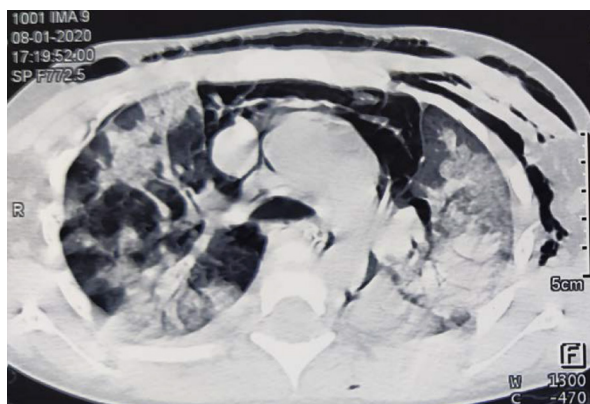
High resolution computed tomography of the chest showing bilateral patches of consolidation
